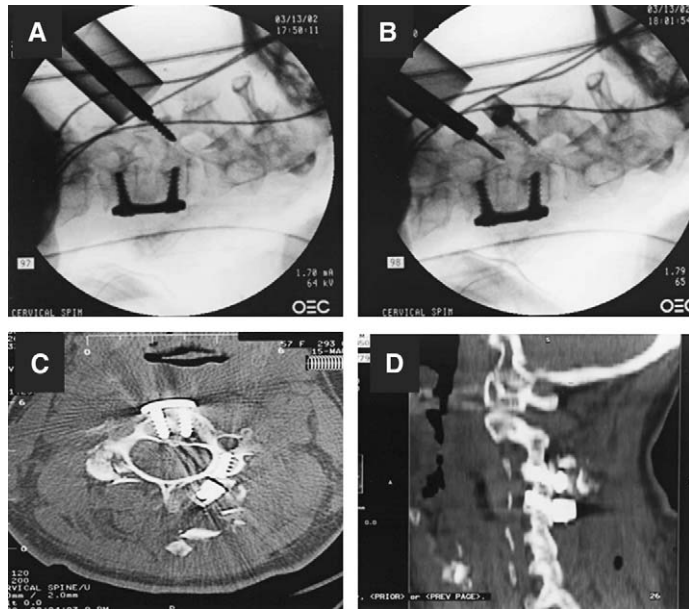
Intraoperative fluoroscopic images (*A, B*) and postoperative CT scan images (*C, D*) of lateral mass screws placed in a minimally invasive fashion highlight the potential of the minimally invasive surgery techniques in the cervical spine. (Courtesy of M. Wang, MD, Los Angeles, CA.)
